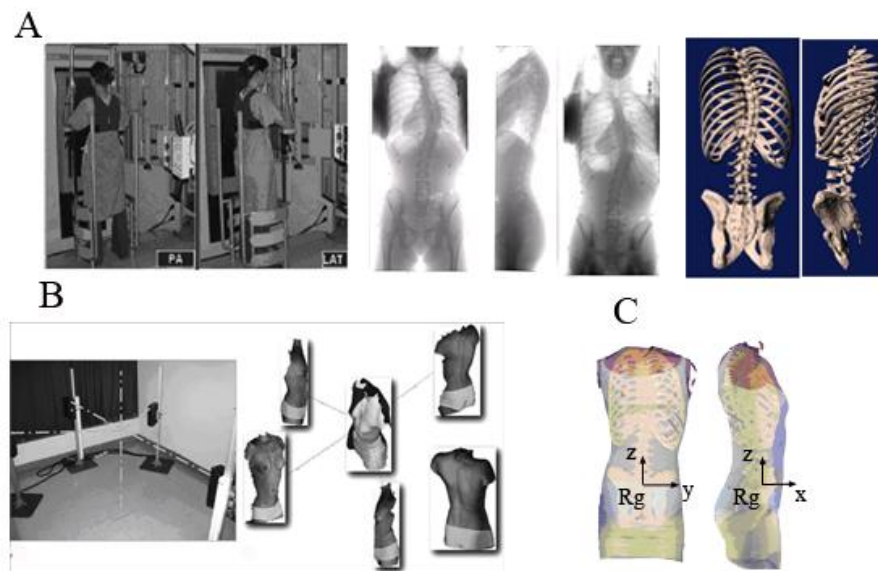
Article 3 Figure 1: A Acquisition of the internal geometry using the multi-view radiographic reconstruction technique; B Acquisition of the external geometry using topography technique; C Superimposition of the two geometries
